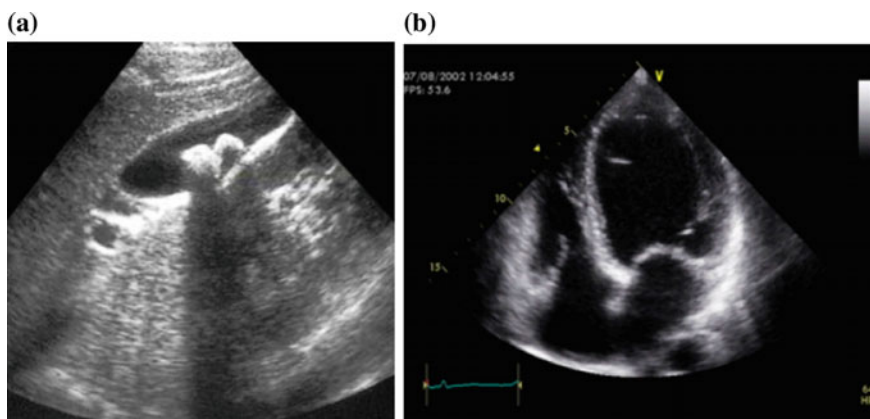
a Ultrasound B-scan of gall stone [1]. b Cardiac image [2]
